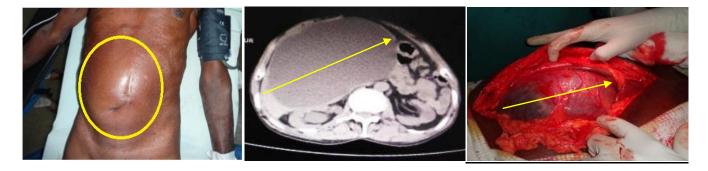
Preoperative picture showing mass in the abdomen occupying the right hypochondrium, epigastric, umblicus and right iliac fossa region. Figure 2 - CT Abdomen shows cystic lesion in right lobe of liver 200x100mm size extending up to pelvis. No septations seen. Figure 3 – Intra-operative picture showing the cyst before aspiration.
